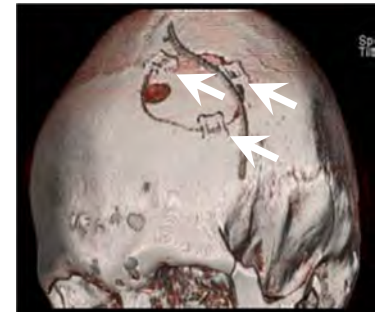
CT surface rendering showing implant positioning.
